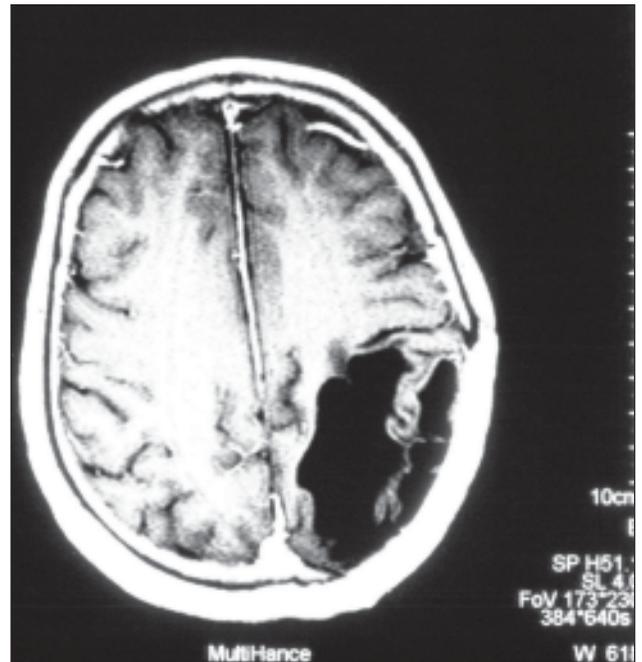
Brain CT from 2008
